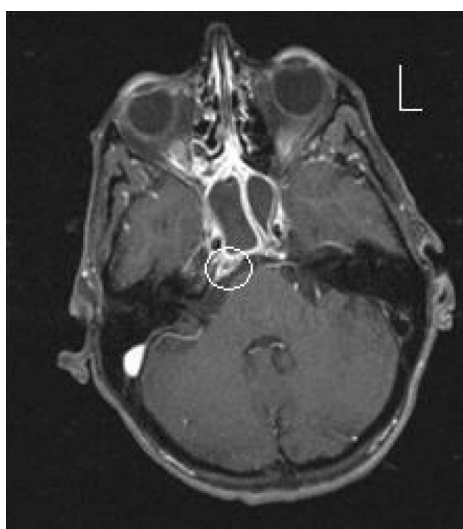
Extension of the inflammation to the clivus on contrast enhanced MRI.
